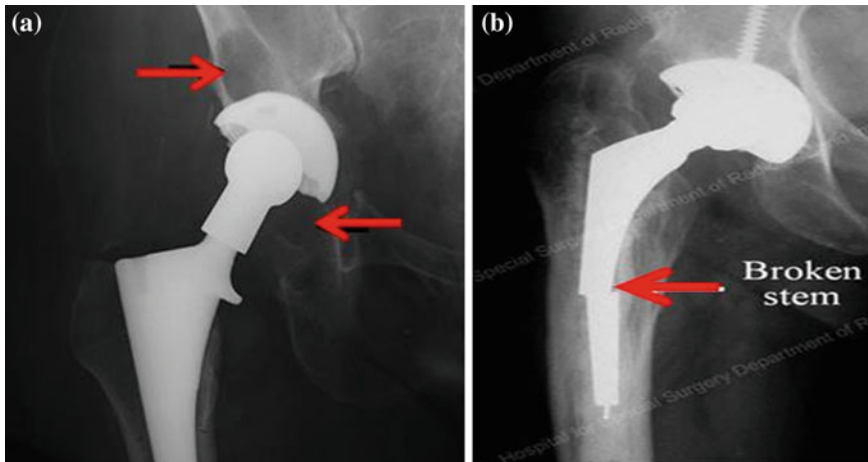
Representative X-ray radiographs revealing two clinical cases caused by a significant mismatch between the host bone tissue and the synthetic implant in total hip replacement surgery: a aseptic loosening ($E_{\text{implant}} > E_{\text{tissue}}$) and b mechanical failure leading to stem fracture ($E_{\text{implant}} < E_{\text{tissue}}$), as indicated by arrow
